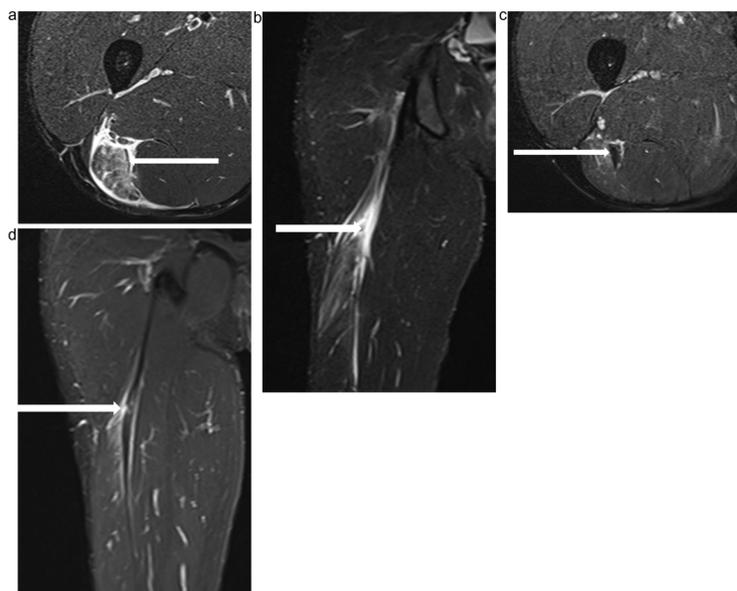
24-year old male soccer player with acute hamstring injury (arrow on each image). Axial (a) and coronal (b) STIR MRI demonstrating high grade injury to the proximal right biceps femoris muscle involving the intramuscular tendon. Follow up axial (c) and coronal (d) STIR MRI at 4 weeks following single dose PRP injection demonstrating reconstitution of the intramuscular tendon and marked reduction in intramuscular oedema.
